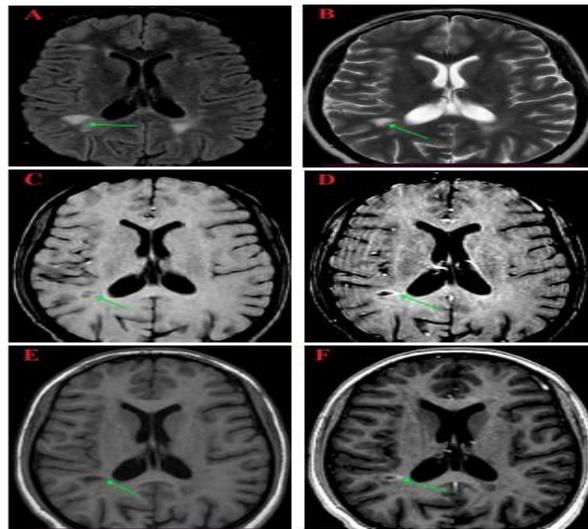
A 22-year-old female patient, presented with right hemi-paresis, headache and generalized weakness of one-week duration. (The initial MRI) A & B): axial FLAIR and Axial T2WI: Show right periventricular and subcortical white matter hyperintense plaques, C): Axial pre contrast SWI: white matter hypointense plaques, D): Axial post contrast SWI: strong ring pattern of enhancement of one plaque which demonstrate BBB dysfunction in the plaque that is characterized more obvious by the GD-SWI sequence, E & F): Axial T1WI (pre and post contrast study): The pre contrast T1WI (D) shows periventricular and subcortical white matter hypointense plaques, the post contrast T1WI (E) shows faint ring pattern of enhancement of one plaque (arrow).
